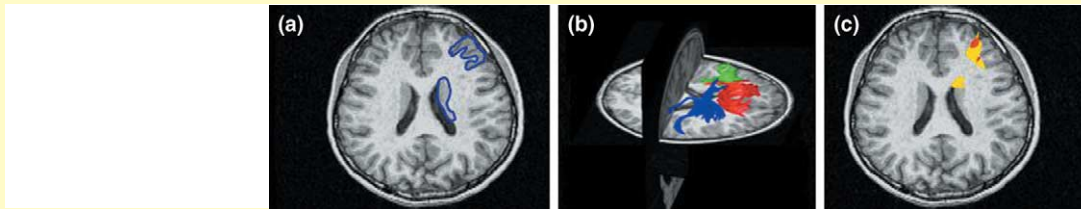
(a) Structural MRI produces structural images of the brain that are useful for anatomical and morphometric studies; (b) DTI measures connectivity of fiber tracts between anatomical structures; and (c) functional MRI measures patterns of brain activity within those structures.
